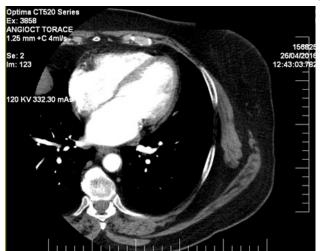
Computed tomography of the heart. Both the right atrium and the left atrium can be seen. Between them the interatrial septum lies. The angle made by the interatrial septum with the horizontal line is approximately 45 degrees, therefore the transseptal needle should be oriented towards 16 o'clock.
